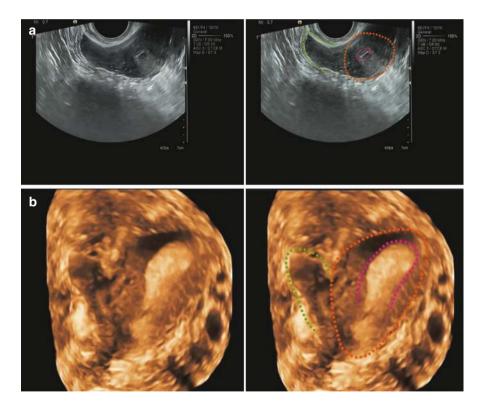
(a) Type III rudimentary horn of the uterus on 2D ultrasound, located on the right side of a unicornuate uterus. It has the same echogenicity as the myometrium and shows no endometrial echoes. The unicornuate uterus is circled in orange; the rudimentary horn of the uterus is circled in green; the endometrium of the unicornuate uterus is circled in pink. (b) A 3D coronal view of the uterine cavity in a unicornuate uterus (on the left side of the rudimentary horn), which appears tubular in shape. The unicornuate uterus is circled in orange; the rudimentary horn is circled in green; the endometrium of the unicornuate uterus is circled in pink
